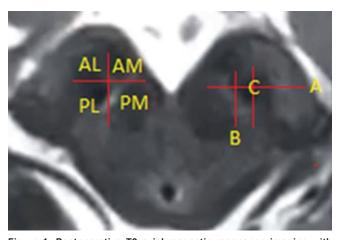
Postoperative T2 axial magnetic resonance imaging with subdivision of STN, A – horizontal line, B – vertical line; AL: Anterolateral, AM: Anteromedial, PL: Posterolateral, PM: Posteromedial, C: Central
